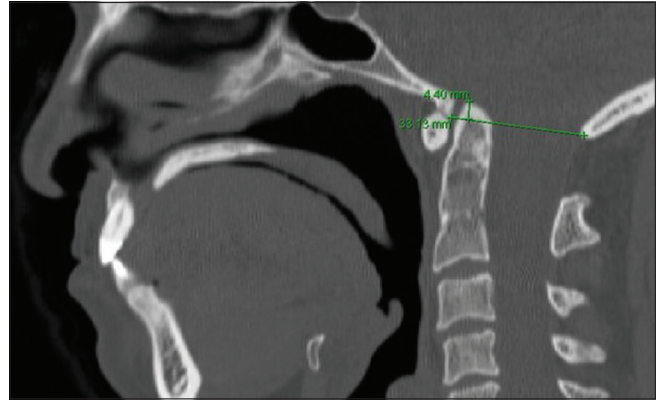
Preoperative lateral cervical spine radiograph demonstrating the McRae line connecting the basion and opisthion.
